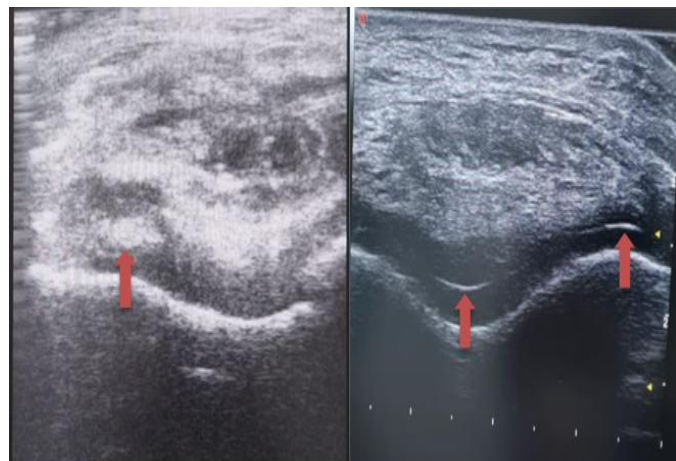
Musculoskeletal ultrasonography showing intra-cartilaginous crystal deposition consistent with CPPD on case 1 (A) and case 2 (B).
